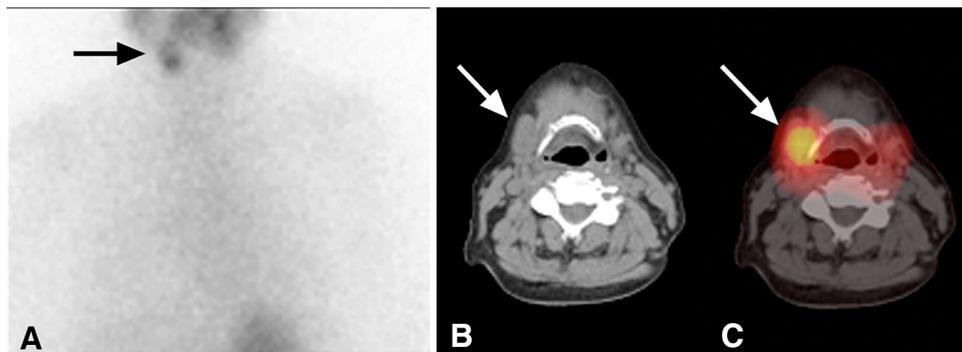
Benign salivary gland activity found in a 78-year-old woman post-total thyroidectomy for papillary thyroid cancer. Diagnostic 4 mCi I-131 planar image (a) demonstrates focal uptake in the right side of the neck suspicious for lymph node metastasis (arrow). Axial CT (b) and SPET-CT (c) localize the neck activity to the salivary
